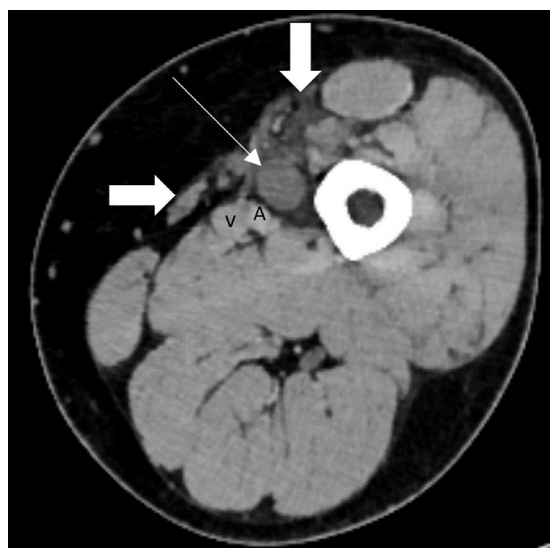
Axial contrast-enhanced CT (level of the middle third of the left thigh) showing significant hypotrophy of the sartorius muscle (white thick right arrow) with medial vastus muscle atrophy (white thick downwards arrow); (white thin arrow- schwannoma, V- femoral vein, A- superficial femoral artery).
